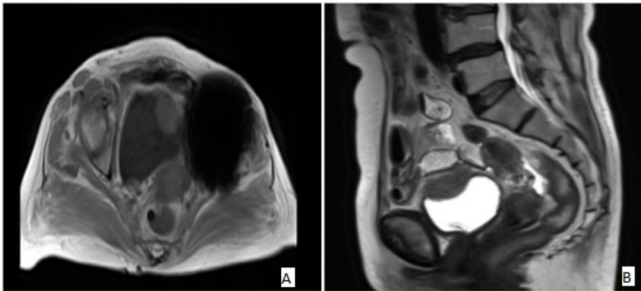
Lower abdomen MRI: Bladder left superolateral mass that can not be distinguish by bladder wall(A, B).
